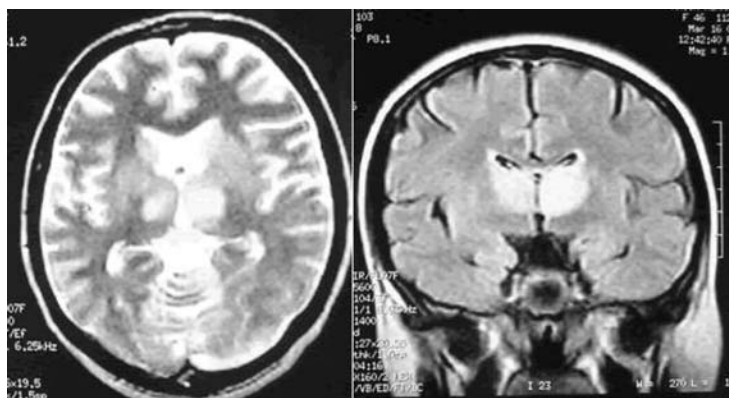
In cranial MRG, hyperintense views which were determined TW2 and FLAIR sequences in bilateral basal ganglia
